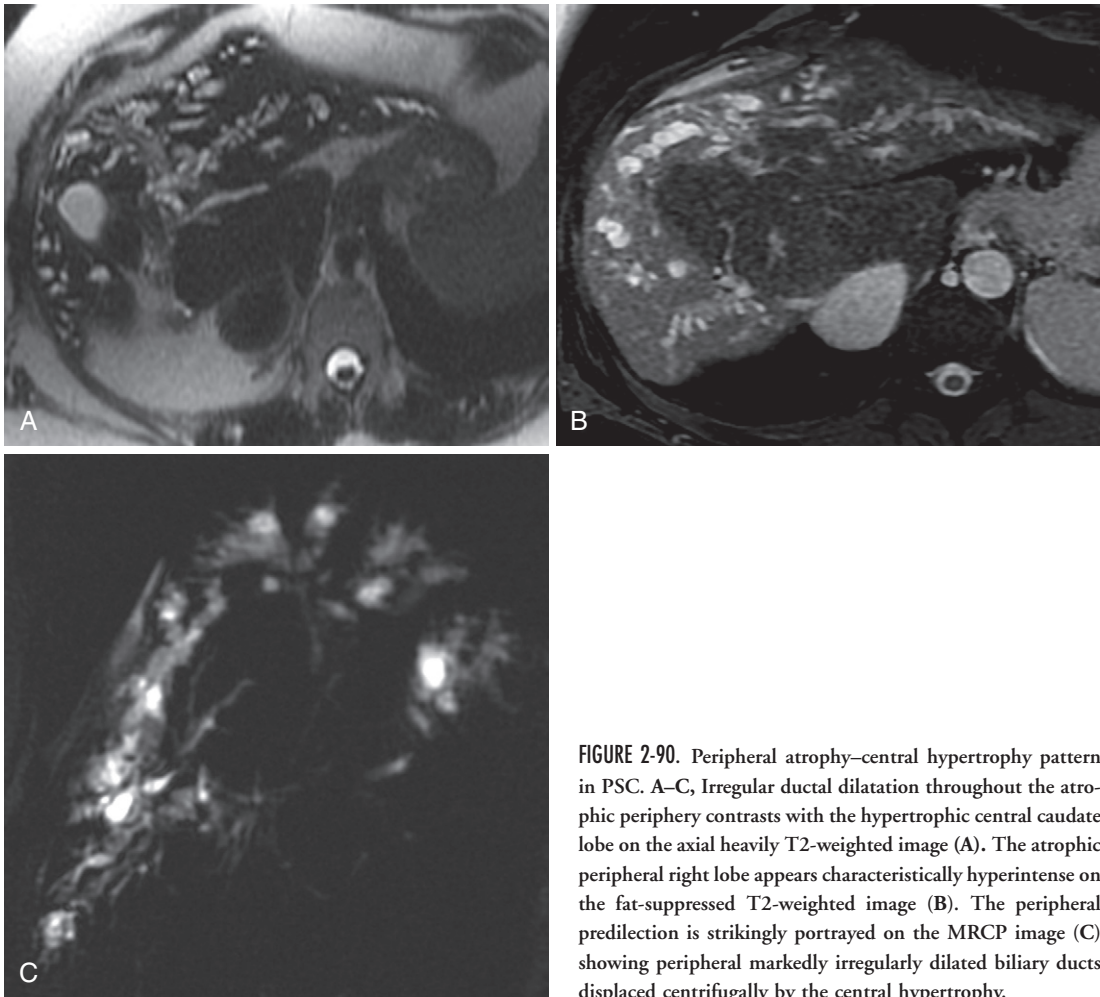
Peripheral atrophy–central hypertrophy pattern in PSC. A–C, Irregular ductal dilatation throughout the atrophic periphery contrasts with the hypertrophic central caudate lobe on the axial heavily T2-weighted image (A). The atrophic peripheral right lobe appears characteristically hyperintense on the fat-suppressed T2-weighted image (B). The peripheral predilection is strikingly portrayed on the MRCP image (C) showing peripheral markedly irregularly dilated biliary ducts displaced centrifugally by the central hypertrophy.
